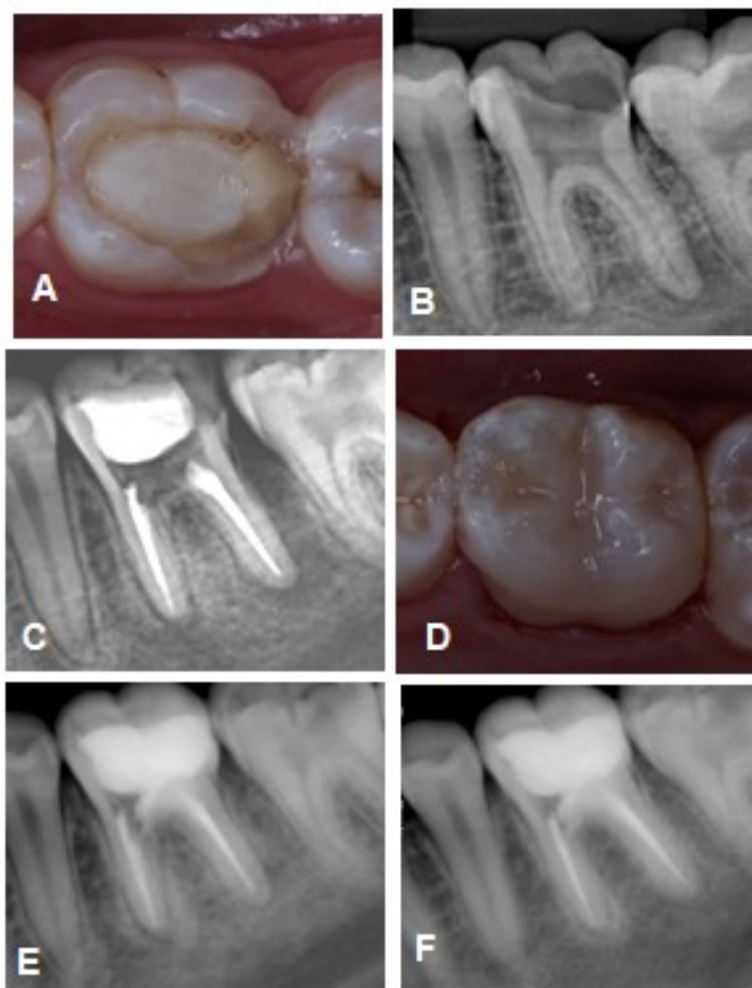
Caso clínico 1; A. Imagem inicial do dente com cárie extensa resultando em comprometimento estrutural; B. Radiografia Inicial evidenciando área radiolúcida periapical na raiz distal; C. Radiografia final evidenciando área radiolúcida apical nas duas raízes e reduzida espessura dentinária no assoalho da cavidade; D. Dente reconstruído com resina composta bulk fill após tratamento endodôntico; E. Radiografia de controle após 6 meses, evidenciando reparo completo da lesão na raiz distal; F. Radiografia de controle após 1 ano mostrando dente completamente reparado.
